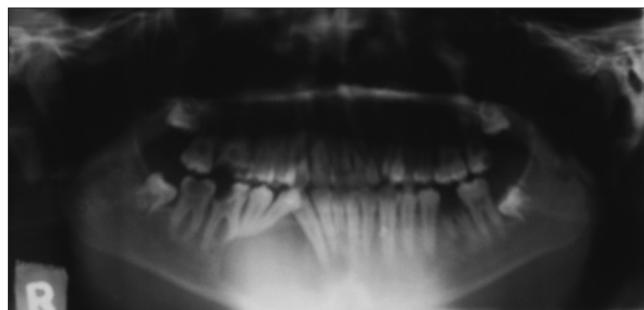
Orthopantomogram showing well-defined radiolucency in the right mandibular body with tooth displacement and root resorption of 43, 44, 45, and 46
